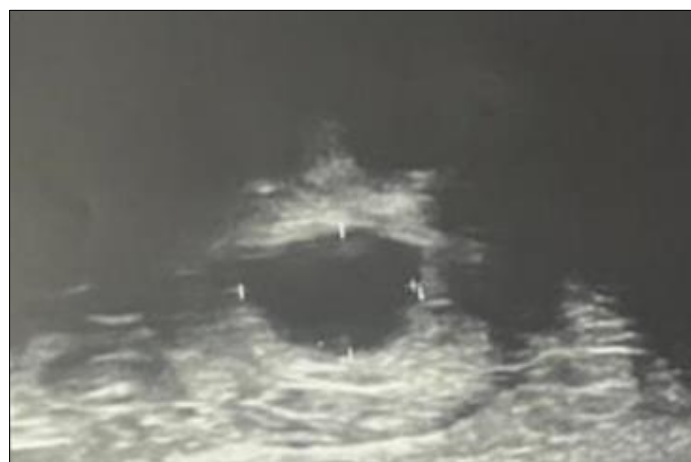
Ultrasound of the sole showing a sub-aponeurotic collection of 35 mm adjacent to the plantar muscles, with thick walls and non-vascularized echogenic content
